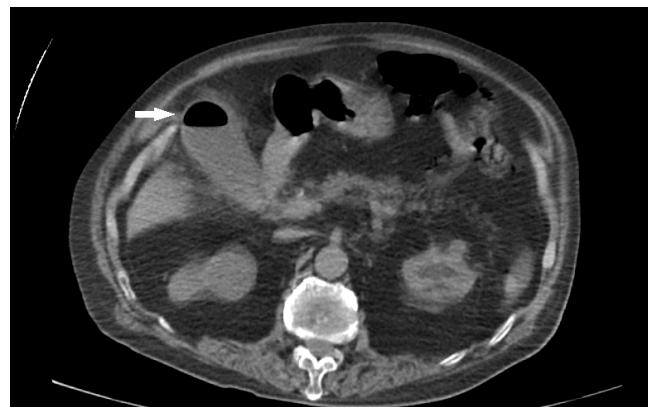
Contrast-enhanced CT of the abdomen. The arrow indicates intraluminal gas within the gallbladder, characteristic of Type I emphysematous cholecystitis, without evidence of wall disruption or perforation.
